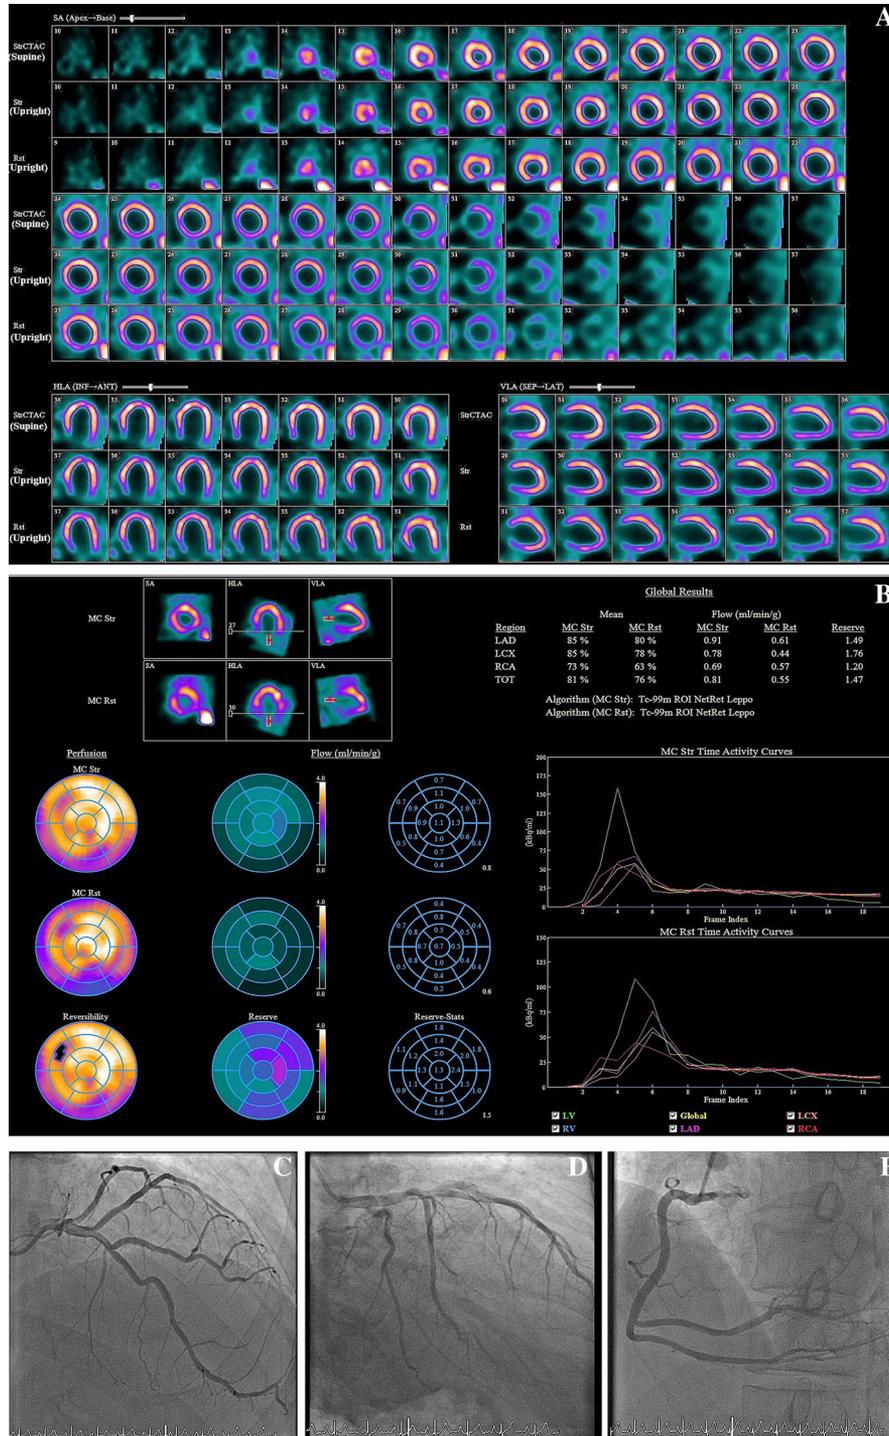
Dilated cardiomyopathy with microvascular dysfunction. A-B 66-year-old Chinese male was admitted for work up for fluid overload. TTE revealed severely reduced LVEF of 20% with dilated LV. Dynamic MPI showed reduced MFR in all coronary territories (LAD 1.49; LCx 1.76; RCA 1.20; Overall 1.47) despite normal perfusion. The stress MBF was reduced in all 3 coronary territories with value of $< 1 \text{ mL} \cdot \text{min}^{-1} \cdot \text{g}^{-1}$. Coronary angiogram showed minor CAD. Overall this is likely a case of dilated cardiomyopathy. Retrospectively, the global reduction of MFR in this case could be due to microvascular dysfunction. Cardiac MRI will be useful to assess for midwall fibrosis as may be present in dilated cardiomyopathy which can also possibly account for the reduction of MFR. He is well tolerating the guideline-directed medical therapy. (C-E) Coronary angiogram showed minor coronary artery disease in mid LAD and proximal RCA with right dominant circulation.
